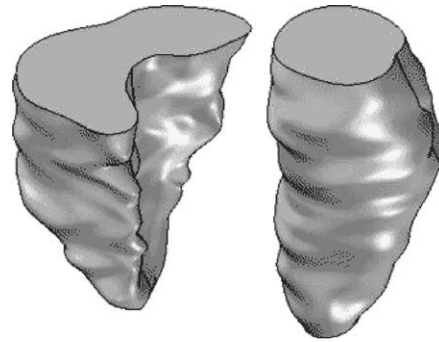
Solid-edge images of the lower portions of ventricle geometries in diastole, reconstructed from MRI measurements.
